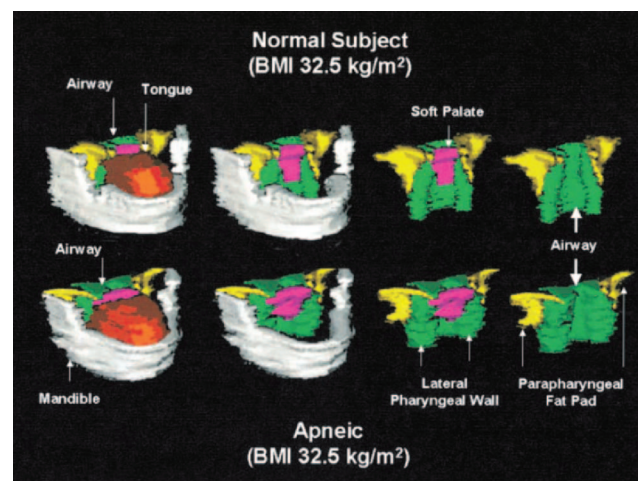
Volumetric reconstructions of the mandible and soft tissue structures from magnetic resonance imaging. Volumetric reconstructions from a series of 3-mm contiguous axial magnetic resonance images of the mandible (gray), tongue (orange/rust), soft palate (purple), lateral parapharyngeal fat pads (yellow), and lateral/posterior pharyngeal walls (green) in a weight-matched normal subject (top) and a patient with sleep apnea (bottom), both with an elevated body mass index (BMI, 32.5 kg/m<sup>2</sup>). Note that the airway is larger in the normal subject than in the apneic subject. The tongue, soft palate, and lateral pharyngeal walls are larger in the patient with sleep apnea. (From Reference 8, with permission.)
